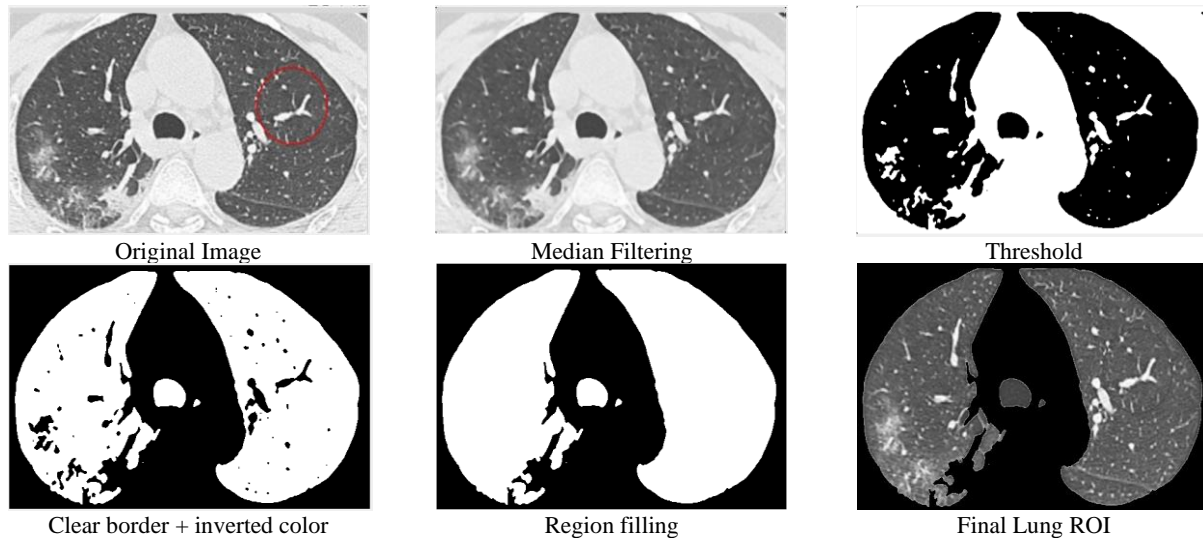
Result of segmenting a lung CT image of the COVID-19 dataset.
